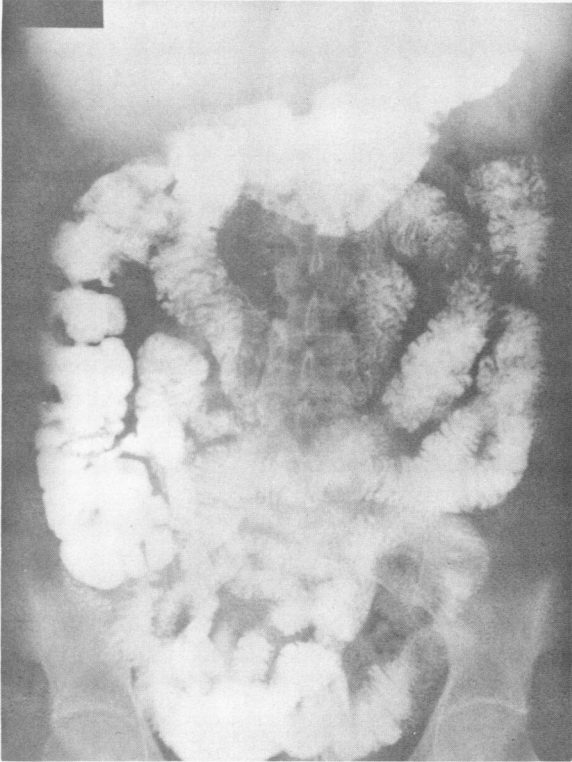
Upper gastrointestinal x-ray study on the eighteenth postoperative day. The distal small bowel shows changes consistent with submucosal edema or hemorrhage.
